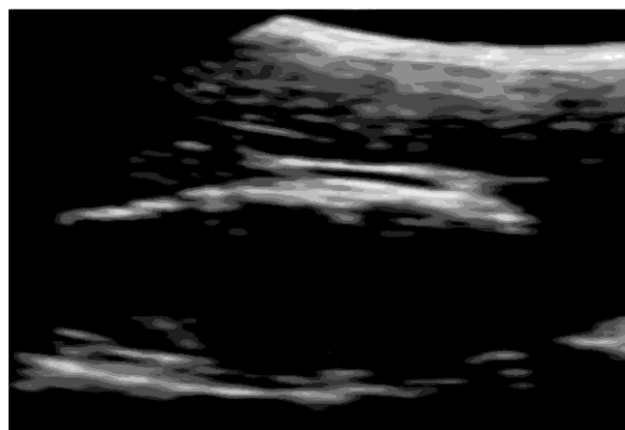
Sonogram. Echonegative cysts type CE5
